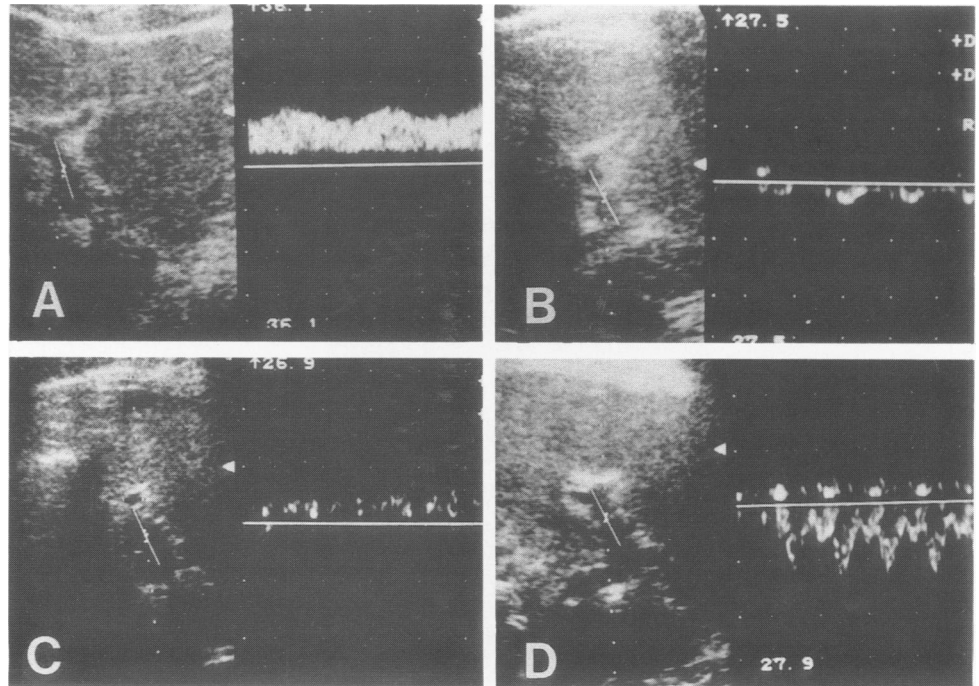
Changes in portal flow direction in patient 1 are demonstrated. (A) The preoperative flow direction in the umbilical portion of left portal branch was hepatopetal. (B) The Doppler shift is displayed below the zero line (arrow) at the time of intra-abdominal hemorrhage because the flow is moving away from the source of the Doppler beam (*i.e.*, reversed hepatofugal flow). (C) The direction of flow recovered to hepatopetal after the hemorrhage was controlled.
